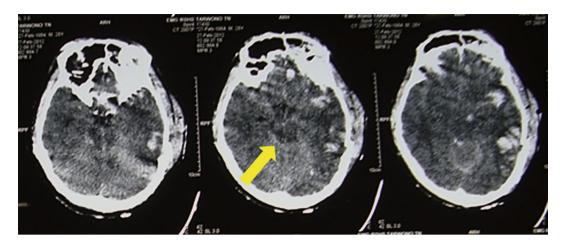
A 49-year-old patient with motoric score of 3 and CT findings showing compression of basal cistern (yellow arrow) on midbrain level and multiple cerebral contusion. Even though patient received adequate treatment but he died after 2 days.
